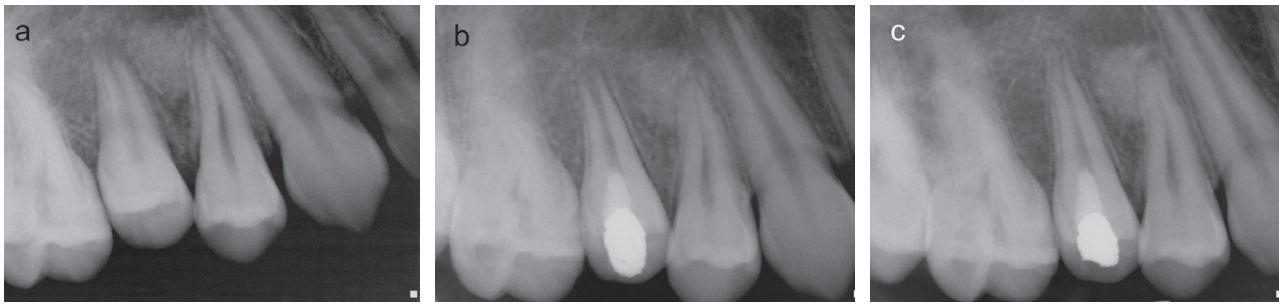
(a) Pre-operative radiograph of an immature root and an open apex in the second maxillary premolar that had been accidentally extracted and then re-implanted. (b) After the placement of platelet-rich plasma and MTA, the tooth was double-sealed with Cavit and amalgam. (c) Radiographic examination of the patient five-and-a-half months later shows resolution of the periapical lesion, further root development, and continued apical closure of the root apex in the second maxillary premolar.
